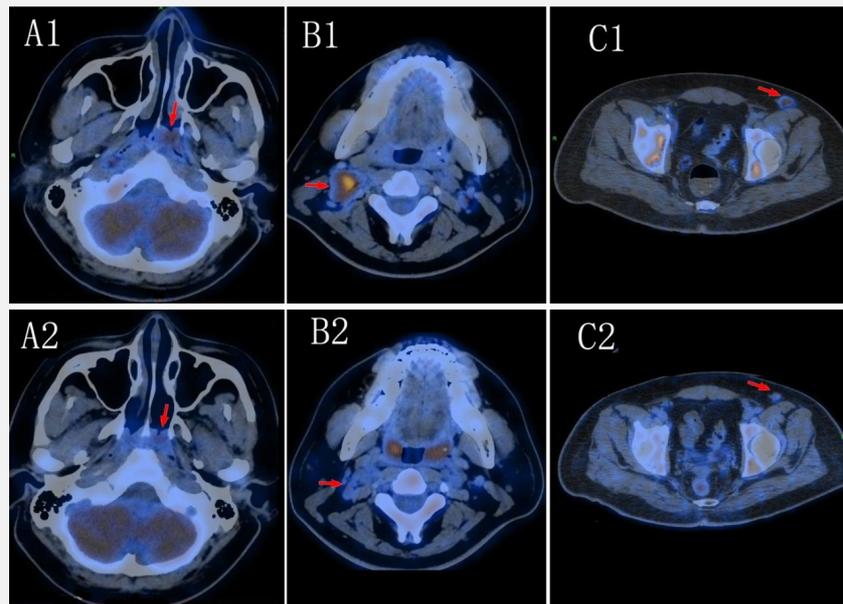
18F-FDG PET/CT imaging changes before and after chemotherapy (arrows).
